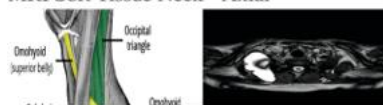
Axial magnetic resonance image of the neck (right panel) demonstrating a well-defined, fluid-signal cystic lesion in the right
